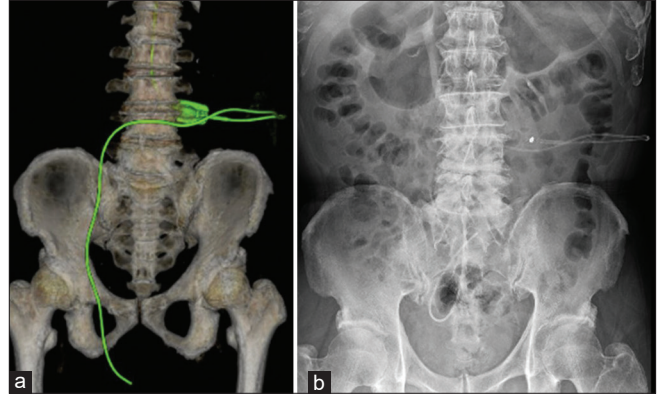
(a) Three-dimensional computed tomography after lumbar catheter reconstruction showing a deviated abdominal catheter in the right inguinal hernia sac. The green structure showing the shunt system. (b) Abdominal radiography on the day after surgery showed a distal catheter in the intraperitoneal space.
